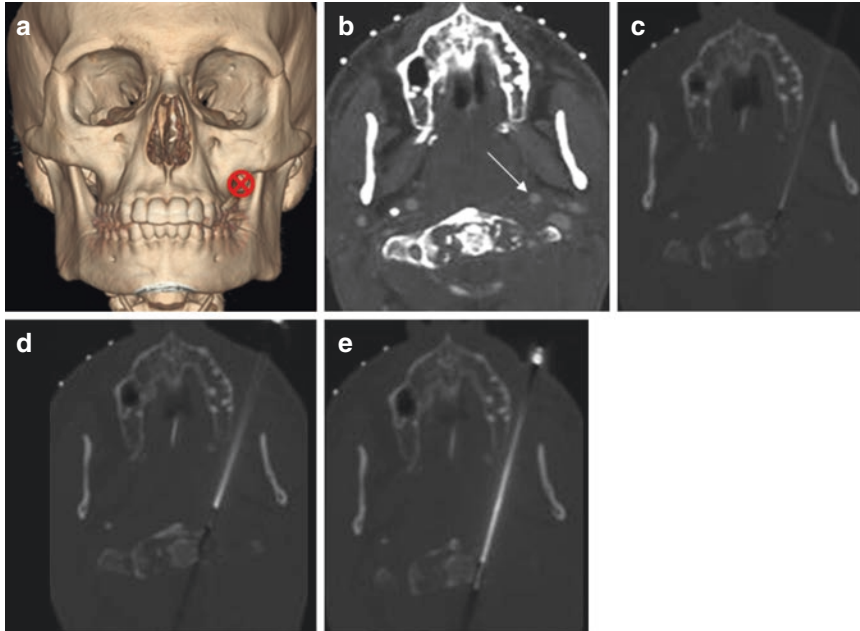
Paramaxillary access to the upper cervical spine: The 3D volume-rendering frontal view CT image of the splanchnocranium (a) shows the entry point (*red crossed circle*) for paramaxillary subzygomatic approach to the upper (C0–C3) cervical spine. The localizing CT scan is usually performed after contrast injection (b) to show the local vasculature structures and plan the safest approach. A long 22 G spinal needle is first inserted (c) medial to the carotid artery (*arrow on b*) and then used as a k-wire to insert a bone access cannula (d). Through the cannula a coaxial biopsy device can be inserted under intermittent CT guidance (e)
